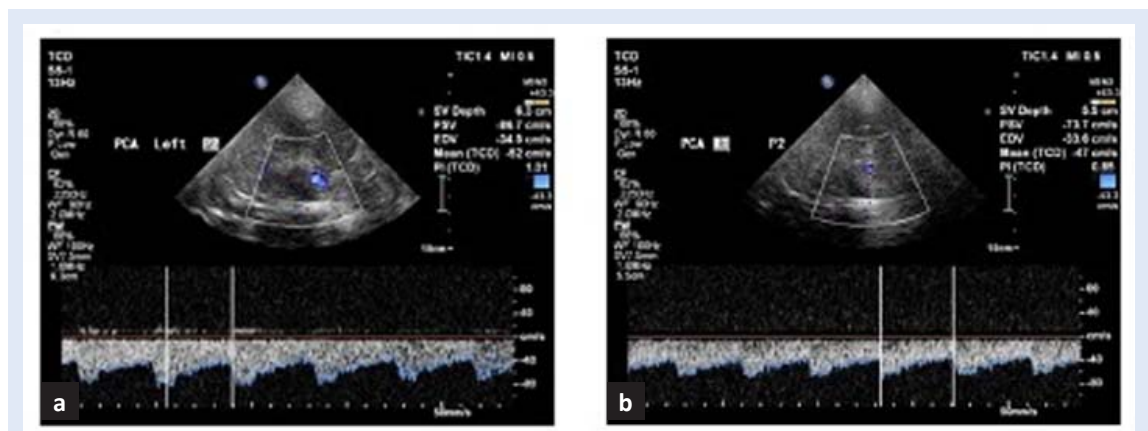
Transcranial color-coded sonography: P2 segment of the right PCA – increased mean flow velocity (MFV) (a), P2 segment of the left PCA – normal MFV (b)
